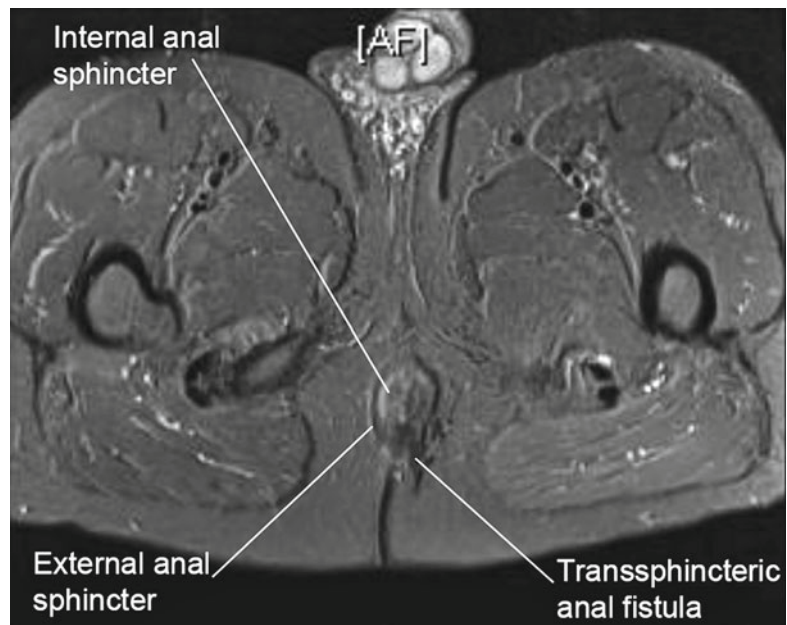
Axial view of a transsphincteric fistula as seen on STIR sequence MRI. The figure above shows an axial section of a STIR sequence MRI. A transsphincteric fistula is seen, with an internal opening at the 6 o'clock position and an external opening at the 5 o'clock position
